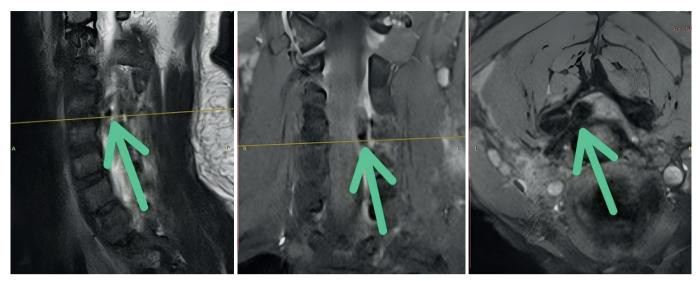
The magnetic resonance imaging results revealed the presence of remaining wood mass located within the intervertebral foramen. The wood mass extended and penetrated the left C3/4 and C4/5 foramen, with its tip touching and compressing the medulla spinalis towards the right.
